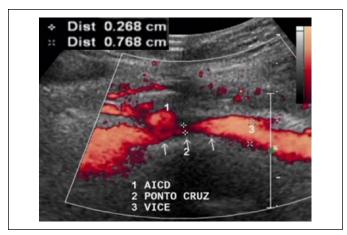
Ultrasonographic documentation of compression of left common iliac vein by right common iliac artery.
